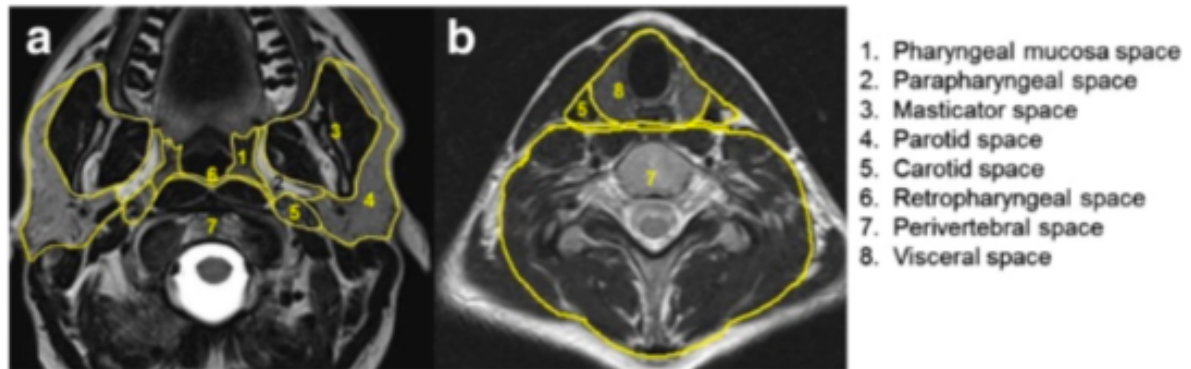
Spaces in head and neck – cross sectional CT image
